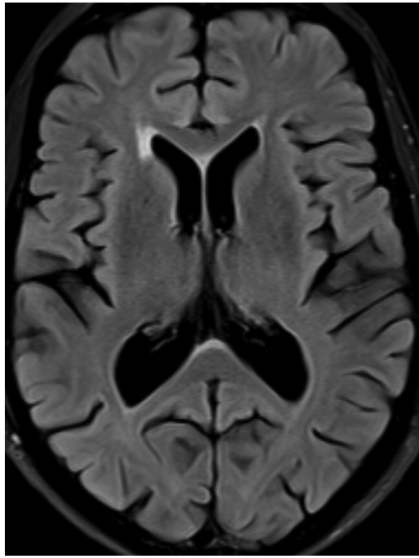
MRI of axial FLAIR sequence with right periventricular increased signal.
